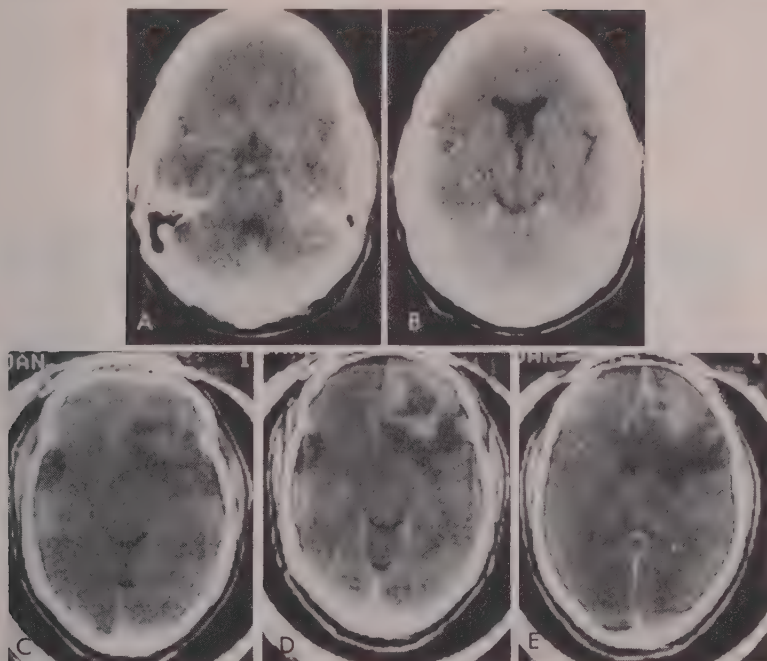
Glioblastoma multiforme. A and B, CECT scans are normal when this 57 year old man first presented with a seizure. C, Non-contrast-enhanced CT scan 6 months later reveals a large low right frontal mass with mixed attenuation. D and E, CECT scans now demonstrate a ring blush with surrounding edema and significant mass effect.
